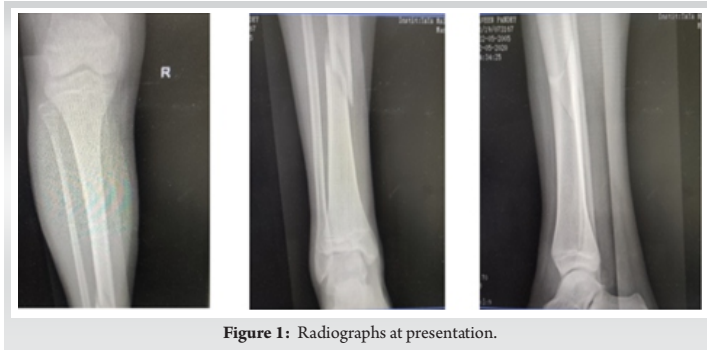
Radiographs at presentation.
